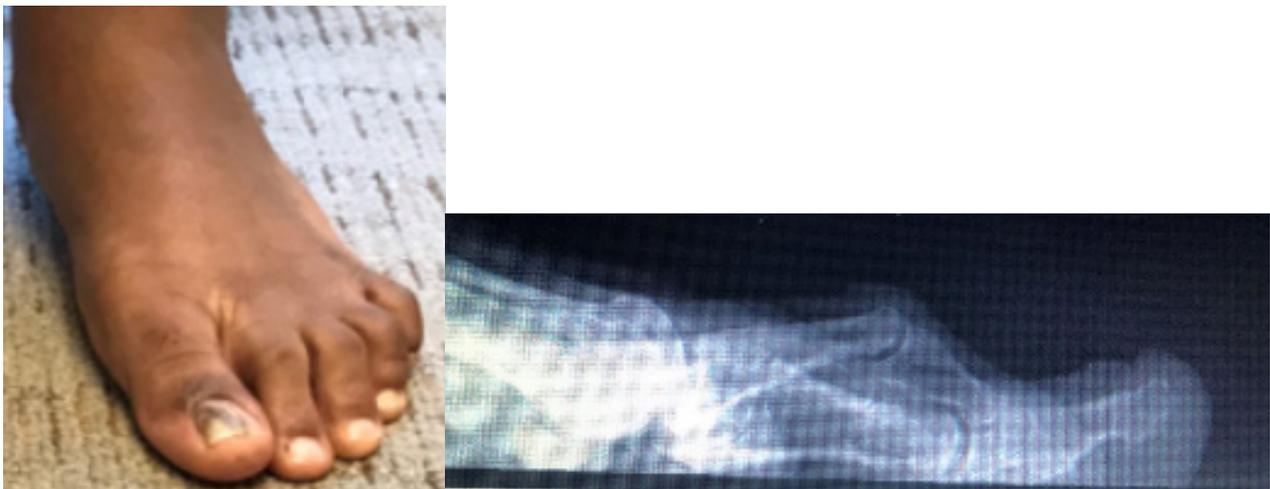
Clinical presentation and X-rays of a woman with a severe bunion on the left foot and a moderate bunion right. The left bunion is also causing alignment changes to digits 2 and 3.
